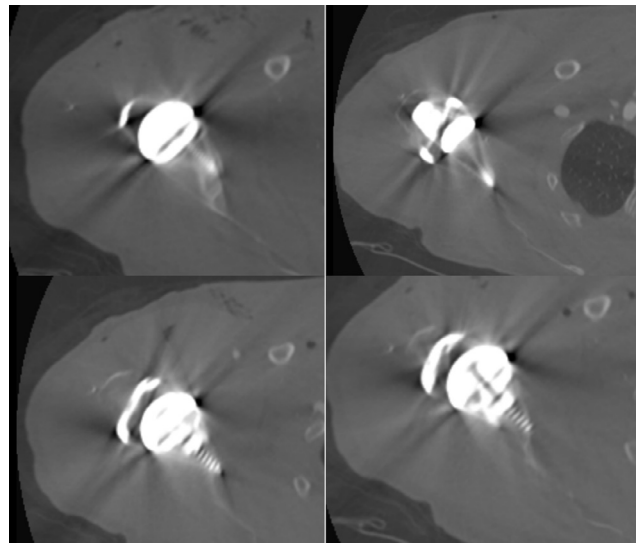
CT scan showing a well-fixed glenoid screw.
